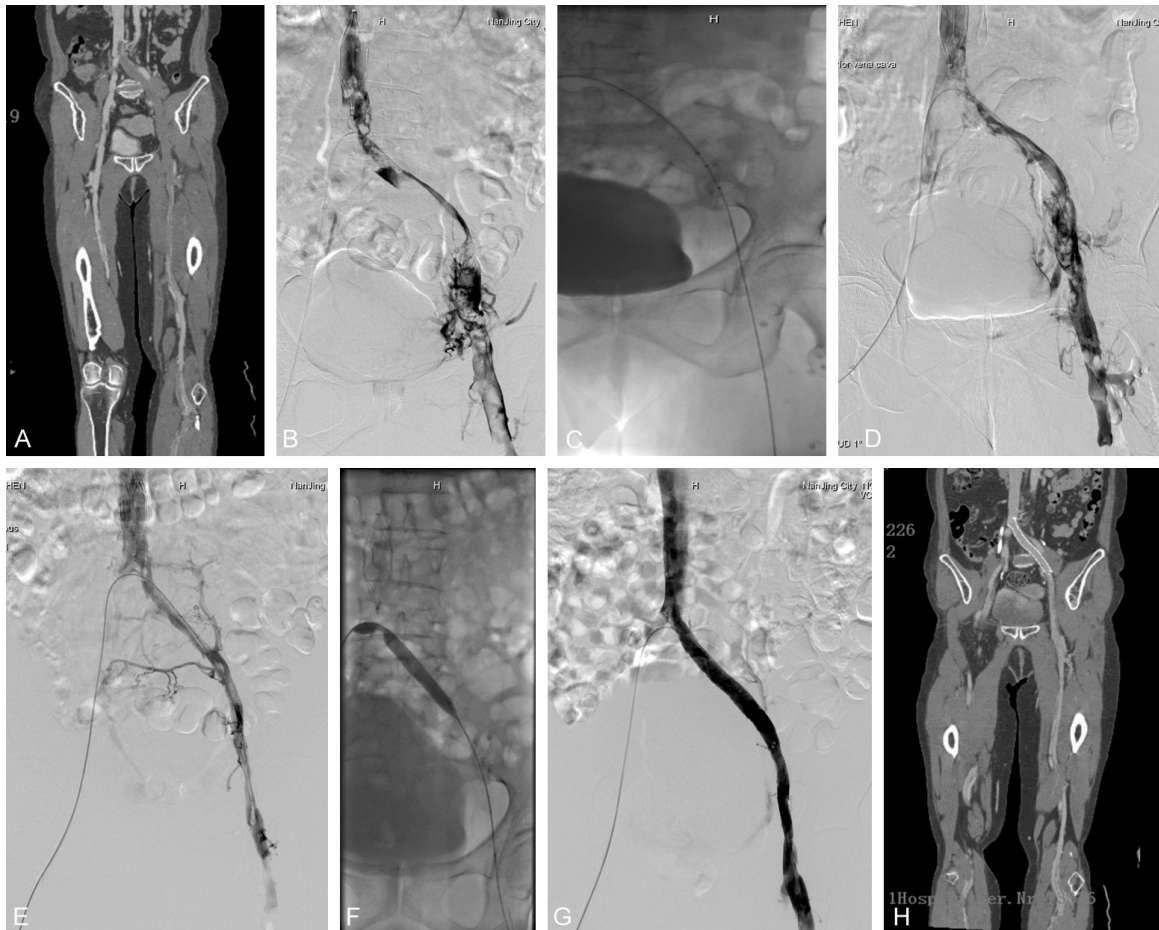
A 67-year-old female that received appendectomy and reported lower extremity swelling after surgery. A. Lower-extremity vein CTA showed left iliofemoral venous thrombosis, which partially extended to the inferior vena cava. B. Inferior vena cava filter was implanted through right femoral vein. Angiography directed by the *cross-mountain* catheter indicated large amount of thrombosis in the left iliofemoral vein. C. AngioJet thrombectomy device was implanted and PMT was performed. D. Thrombus in the iliofemoral vein was significantly reduced after surgery. E. Thrombolytic catheter was retained and the review 72 hours later showed that the thrombus in the iliofemoral vein was basically removed. Moreover, left iliac vein compression was observed. F, G. Stent (12×80 mm) was implanted. Angiography showed complete recovery of the fluency in the left iliofemoral vein. The inferior vena cava filter was removed. H. CTA review at 6 months after surgery showed patent blood flow in the iliofemoral vein, with satisfactory stent position.
